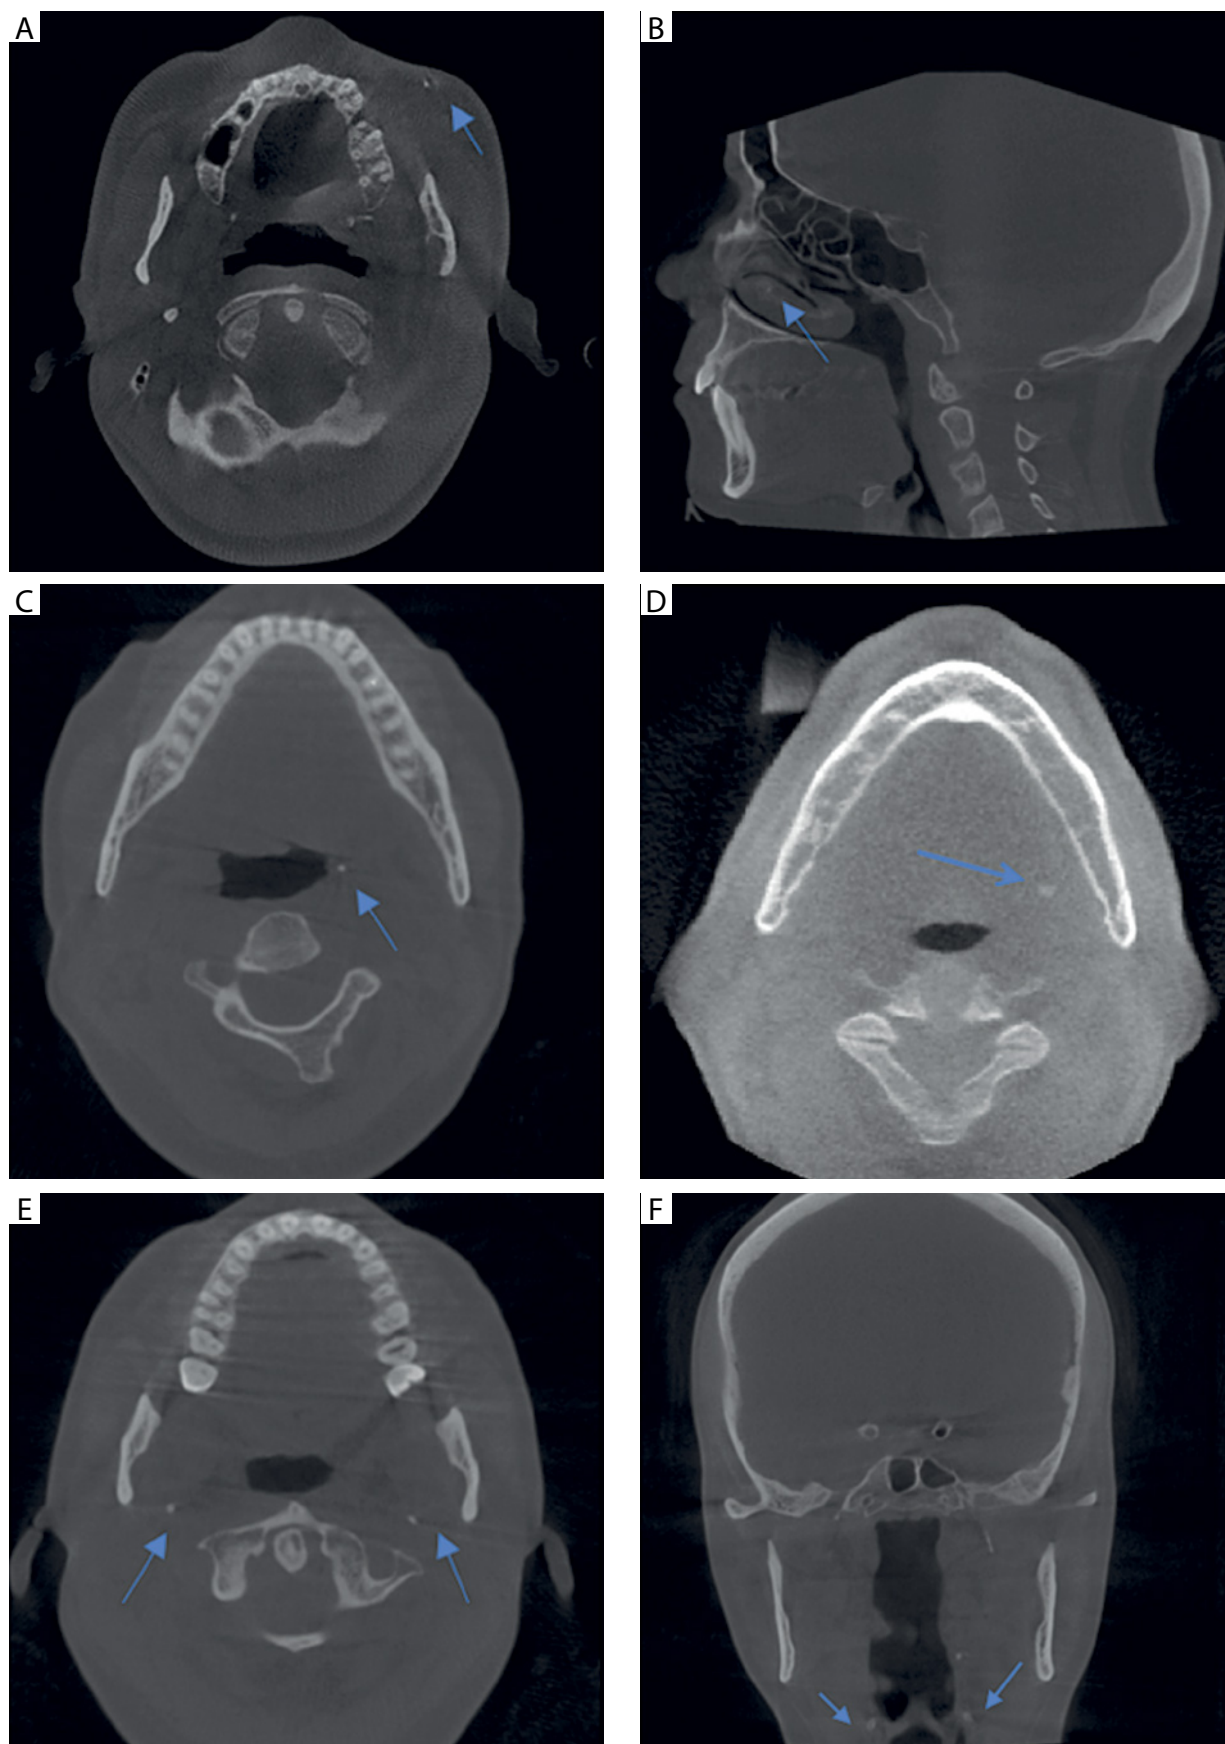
A) Cone-beam computed tomography (CBCT) image of osteoma cutis. B) CBCT image of nasal cavity calcification. C) CBCT image of tonsilloliths. D) CBCT image of sialolith. E) CBCT image of calcification of styloid ligament. F) CBCT image of calcification of styloid ligament
